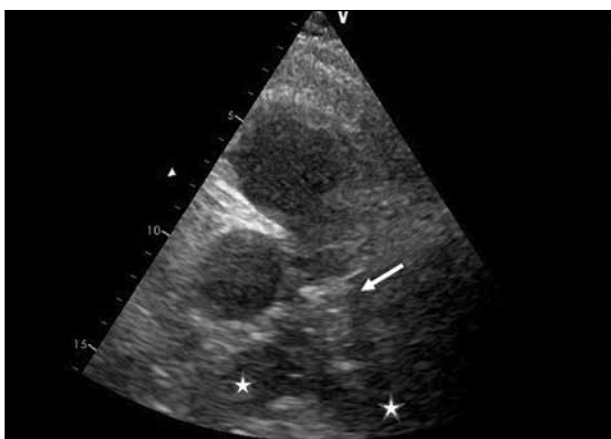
Parasternal short axis view of the pulmonary artery. The stars indicate the right and left pulmonary artery. The white arrow indicates the thrombus lying on the bifurcation of the pulmonary artery.
